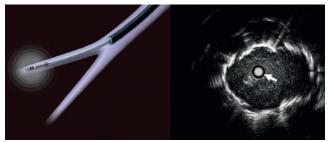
Radial probe endobronchial ultrasound (*left*). A radial probe is surrounded by lesion (*right, arrow*). (*Left* from http://www.goldcoastrespiratoryandsleep.com.au/gcrsc-services.html.)
